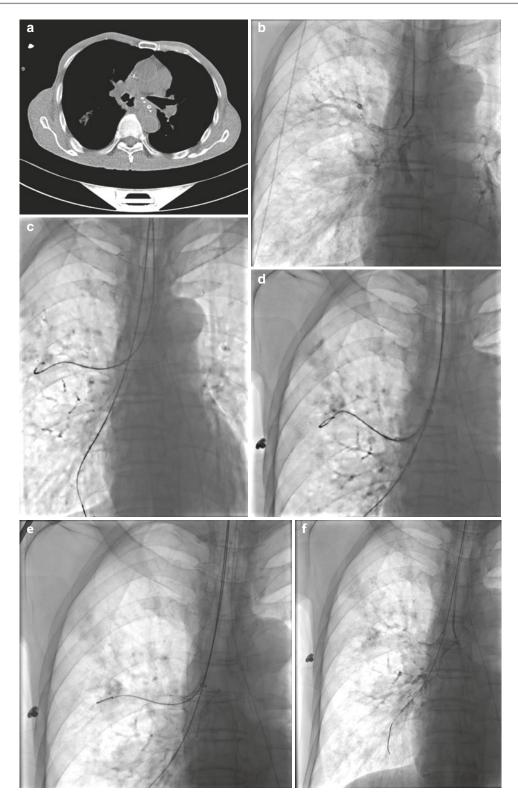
The treatment of one case of thoracostomach - right middle bronchus fistula (a) chest spiral computed tomography (SCT) before intervention showed a thoracostomach–right middle bronchus fistula (b) airway radiography showed features of the fistula similar to those seen on SCT (c-e) a small Y-stent insertion (f) airway radiography showed that the fistula had disappeared
